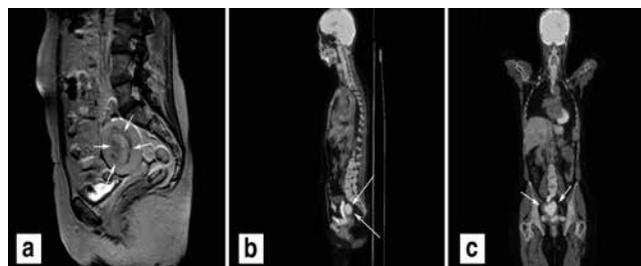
T1W sagittal MR image showing the lesion that fills the endometrial cavity and invades the myometrium (arrows) (a). Coronal (b) sagittal (c) PET/CT images showing hypermetabolic mass lesions in the endometrium SUVmax: 19.2
